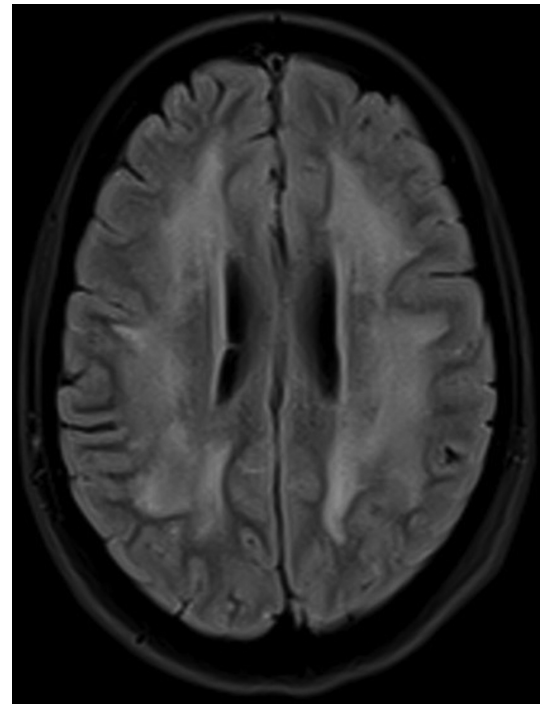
MRI image. T2 fluid-attenuated inversion recovery (FLAIR) sequence showing bilateral symmetrical and confluent white matter lesions.
